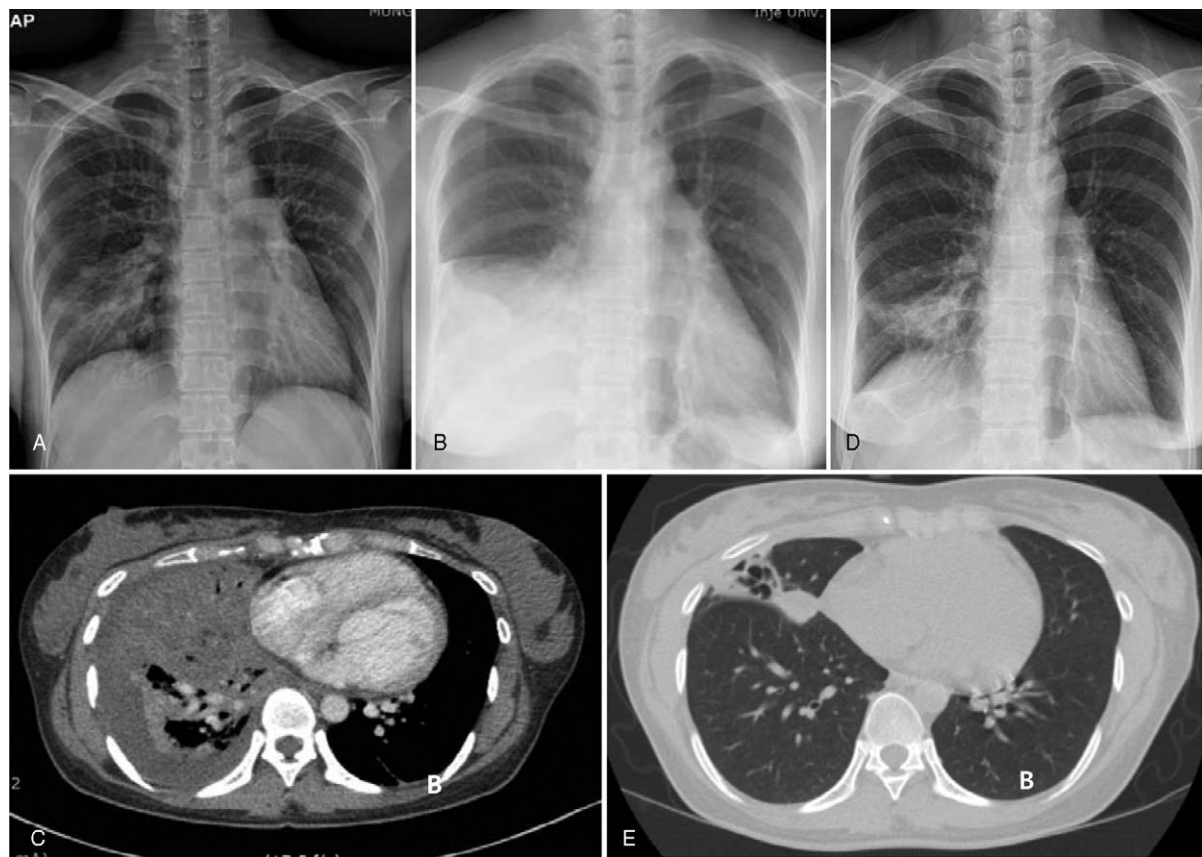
(A) Chest radiography revealed reticular opacity in right mid and lower lung fields. (B) Newly developed right pleural effusion and right middle and lower lung consolidation. (C) Chest computed tomography scans revealed a necrotic consolidation in the right middle and lower lobe with right pleural effusion. (D) Nearly disappeared right pleural effusion and improving of consolidation. (E) Obviously decreased necrotic consolidation in RML and resolution of consolidation of RLL, right pleural effusion. But, newly developed multiple pneumatoceles in RML.
